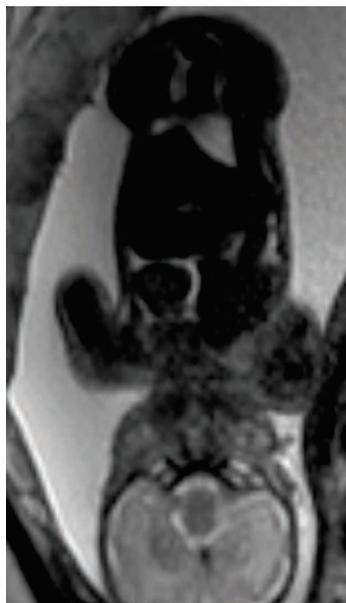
Coronal T2W MRI image that evidences the pericarditis
